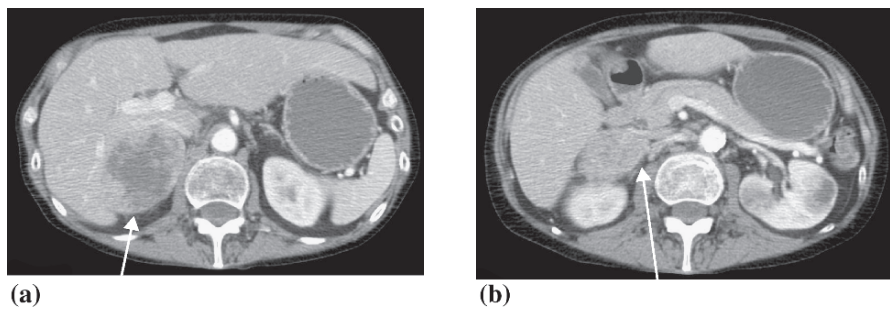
Adrenal carcinoma. Large irregularly enhancing adrenal mass (a) on contrast-enhanced CT with evidence of invasion of the IVC (arrow) (b) and demonstrated delayed retention of contrast consistent with an adrenal carcinoma
